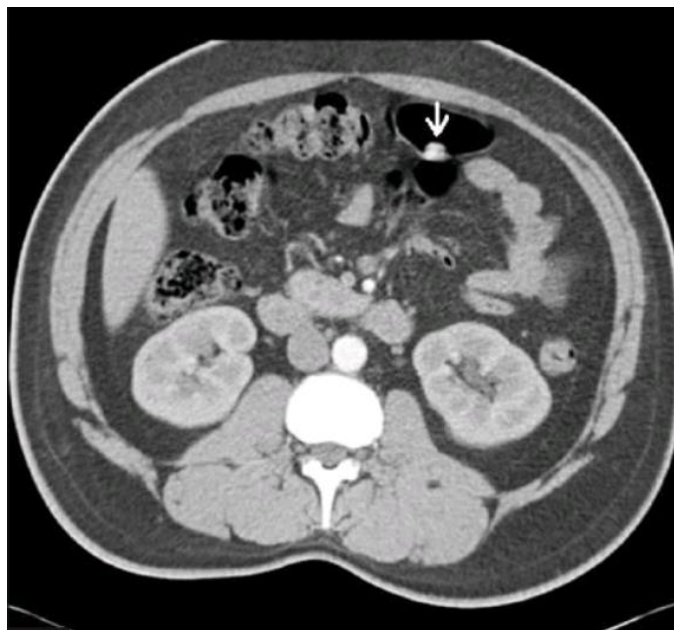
A CT scan of an abdomen showing a lesion on the bowel wall. The small dense lesion is shown with an arrow and is white. CT images are cross sectional and the spine and aorta are in white at the bottom of the image and the black patches are air in the bowel.
